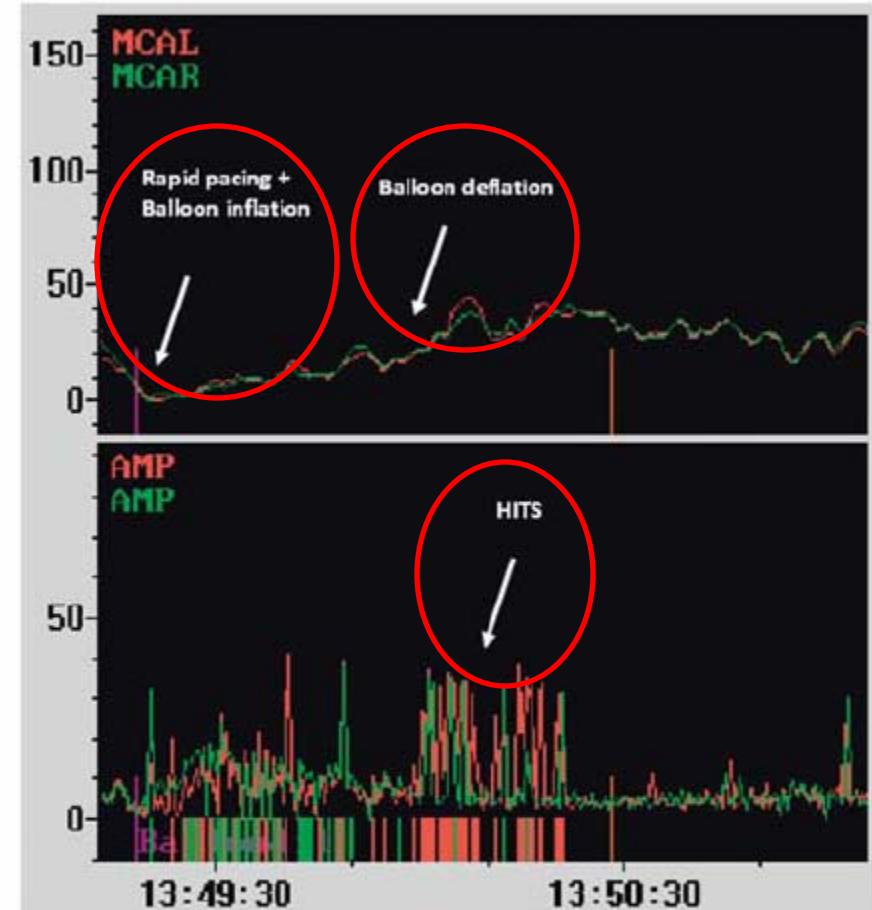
Typical screen findings of transcranial Doppler examinations during balloon valvuloplasty. The upper screen shows flow velocity in the left (MCAL) and right (MCAR) middle cerebral artery. The lower screen (AMP) shows flow accelerations corresponding to potential embolic signals.
